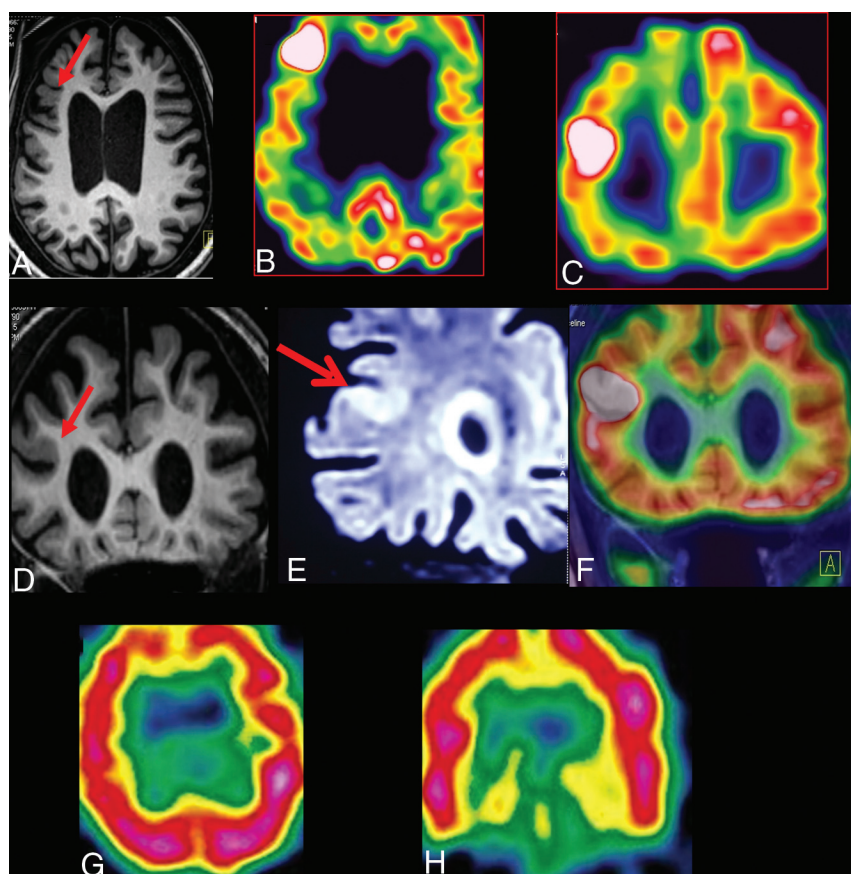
A case of refractory epilepsy with daily seizures of 21 years' duration with moderate mental retardation. Brain MR imaging 3D-T1 volume fast-field echo sequences of axial (A), coronal (D), and coronal (E) 3D-FLAIR volume show a right middle frontal gyrus cortical laminar architectural abnormality with cortical thickening (arrow). The MR imaging abnormality was detected retrospectively after the FDG-PET (B and C) and MR imaging/FDG-PET coregistration (F) showed the focal hypermetabolic focus. The ictal SPECT (G and H) findings were inconclusive.
